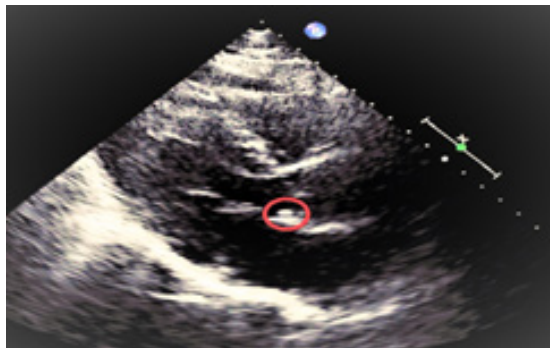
Transthoracic echocardiogram, Red circle shows the density in the LVOT (artifact vs calcification).
